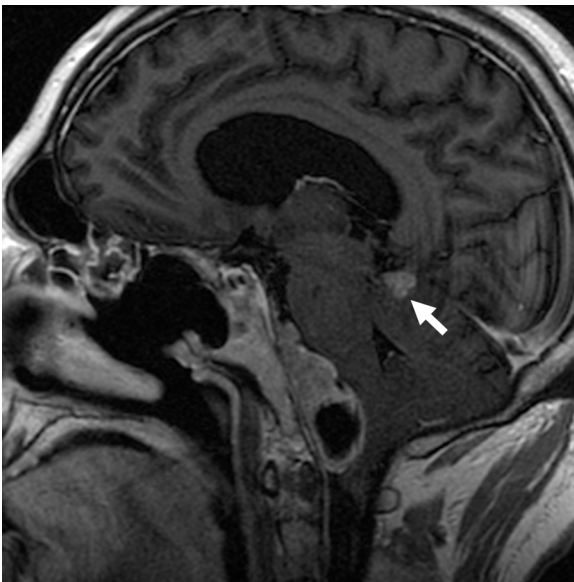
Sagittal Fluid Attenuated Inversion Recovery (FLAIR) T1w + Gd from February 2020 that reveals a huge increase of the heterogeneous petroclival tissue obliterating periaxial cisterns with mass effect on the brainstem. A dural metastasis is also appreciable (arrow).
